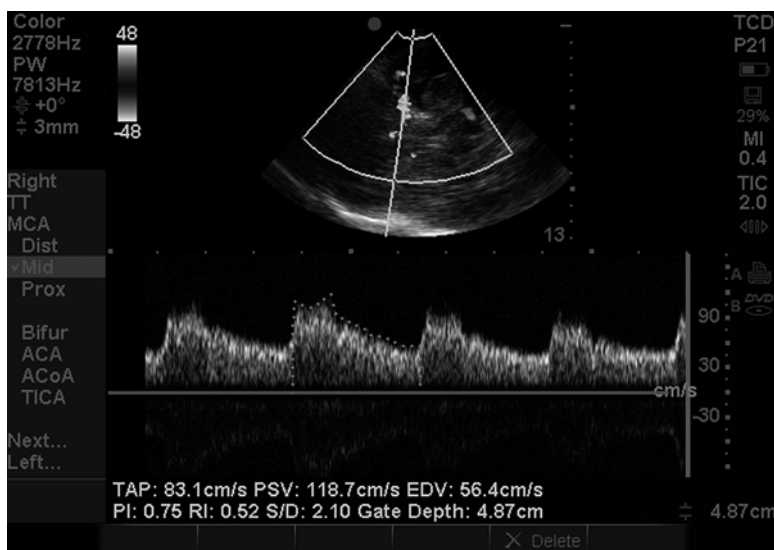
Spectral Doppler waveform. Spectral Doppler waveform obtained from sample volume placement on MCA shown in Fig. 15.13. The mCBFV is depicted here as the time averaged peak (TAP). *PSV* peak systolic velocity, *EDV* end-diastolic velocity, *PI* pulsatility index
